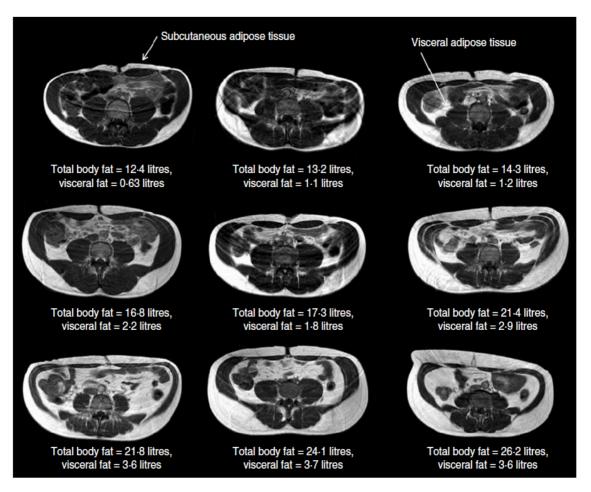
Axial MRI images at the level of the umbilicus of 9 males who have equivalent BMI levels of 24 but greatly varying SAT and VAT levels (Thomas et al., 2012a).
